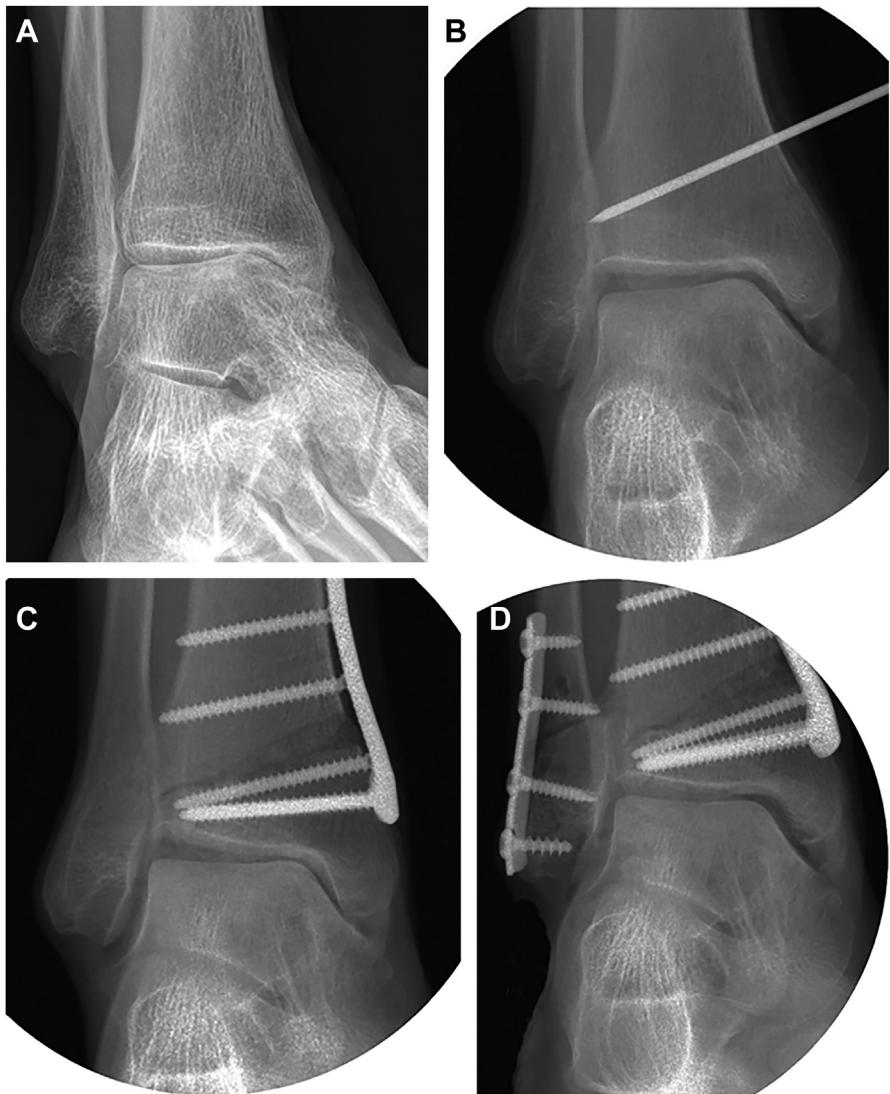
The effect of a fibular osteotomy. A 62-year-old very ambitious marathon runner who is suffering from progressive medial ankle pain after having sustained several ankle sprains in the adolescence. (A) The AP radiograph shows a narrowing of the joint space at the medial corner in the roof of the dome of the talus and an obliteration only at the tip of medial malleolus preoperatively with an angle of talar tilt on weight-bearing of 6°. (B) Intraoperative fluoroscopy of the nonloaded ankle with a Kirschner wire placed where the medial open wedge osteotomy is planned. (C) After having performed the correcting osteotomy of the distal tibia, the talar tilt angle increased to 11° despite of a Broström type reconstruction of the lateral ankle ligaments. (D) A shortening osteotomy of the fibula with some valgus angulation was needed to achieve a congruent ankle joint.
